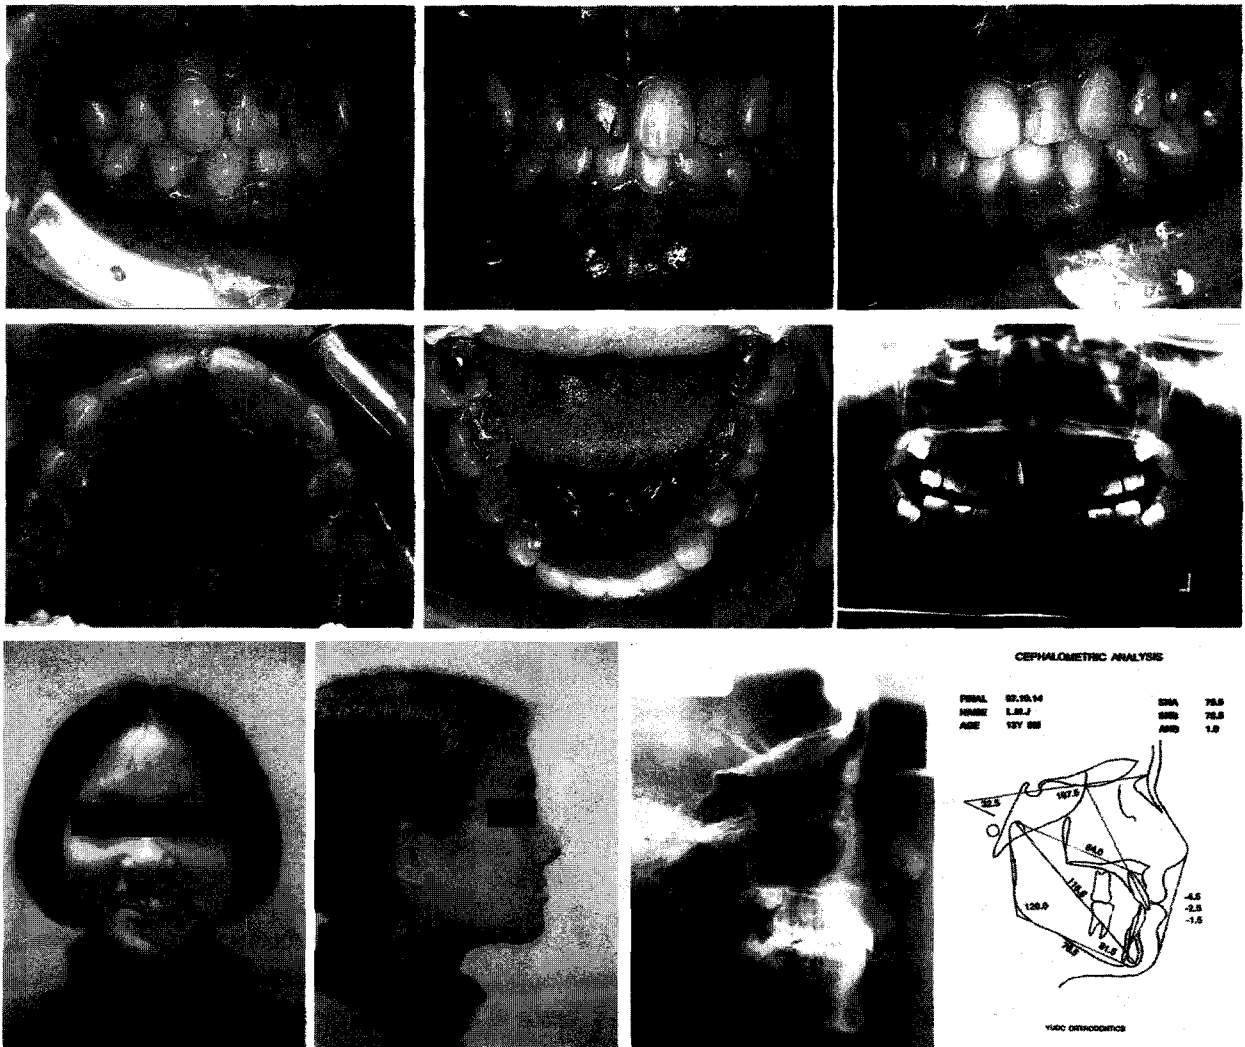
post-treatment intraoral, extraoral photos and X-ray of case 1
